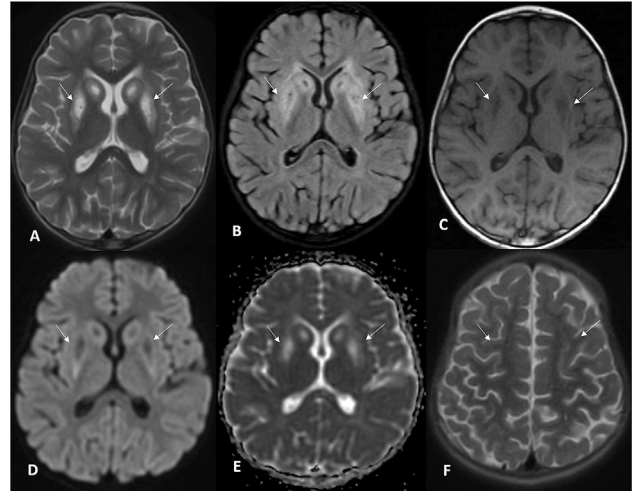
Follow up MRI after treatment revealed regression of the previous abnormal high T2 (arrows in A) & FLAIR (B) signal involving both basal ganglia and medial thalami with resolution of the high central signal at T1 (C). Normalization of the diffusion restriction with low signal on DWI (D) and high signal on ADC (E). Also, resolution of the previous bilateral high frontoparietal cortical high T2 signal (arrows in F).
